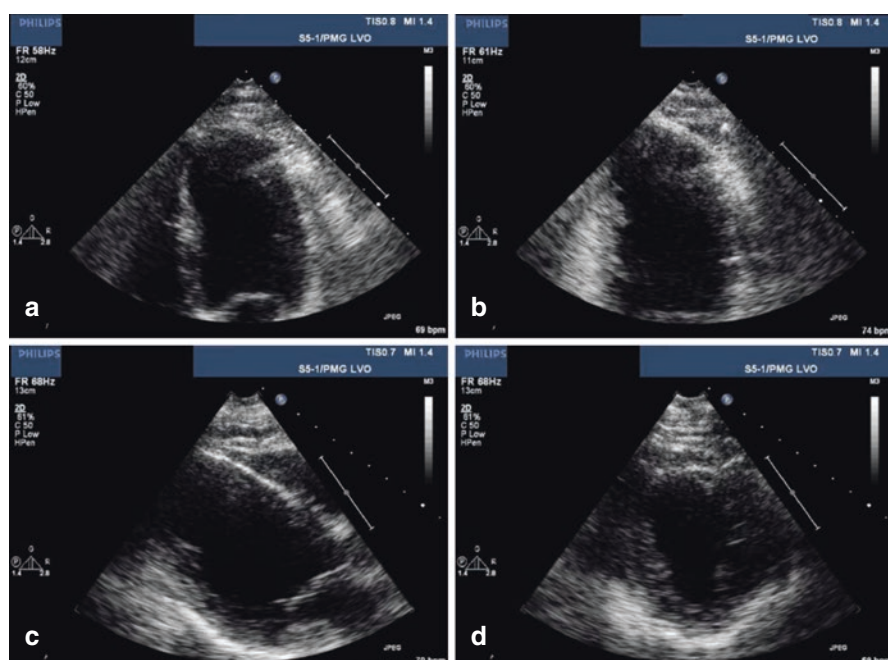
Unenhanced apical four-chamber (a), apical two-chamber (b), parasternal long-axis (c), and parasternal short-axis (d) views
